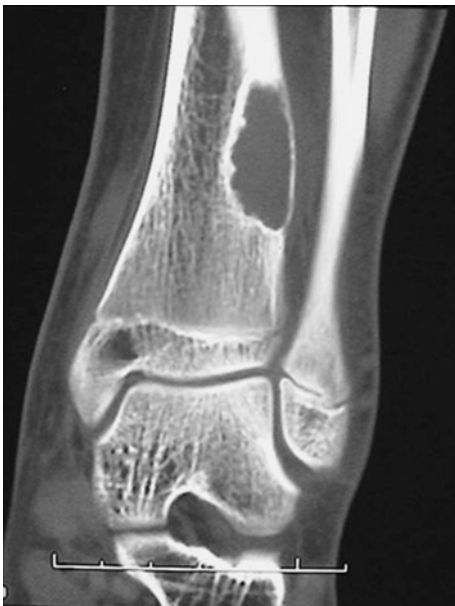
CT scans showed an irregular lytic area with well-defined surrounding sclerotic bone
